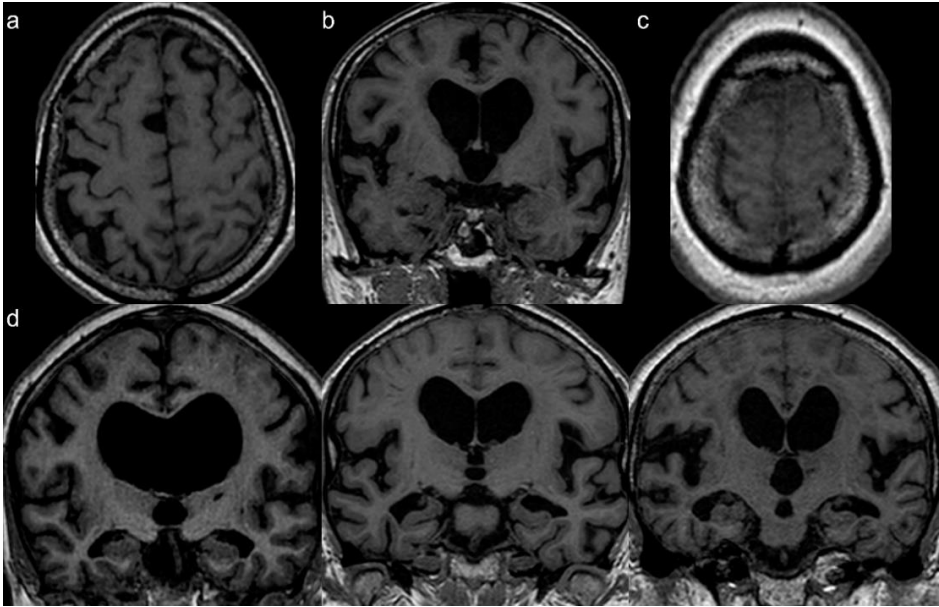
Focally dilated sulci on a transaxial (a), and coronal image (b). Obliterated sulci at the high convexity (c) on transaxial images. Sylvian fissures graded as 0 (normal), 1 (slight widening), 2 (marked widening) on coronal images (d). All images are T1-weighted.
